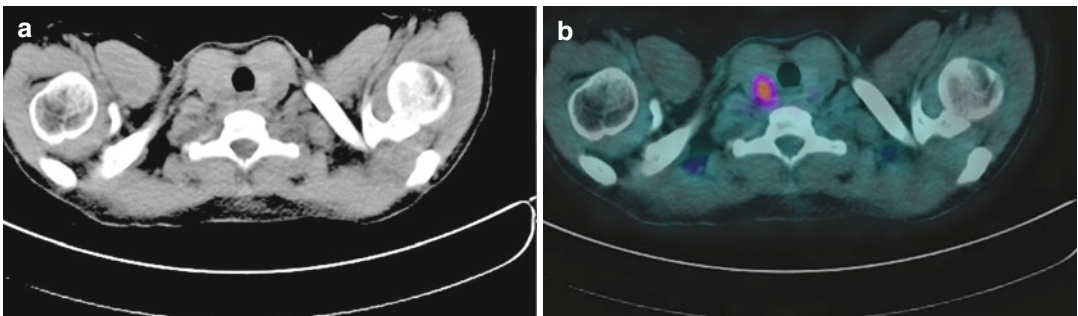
FDG PET-CT scan of a 45-year-old woman with a solitary 10 mm lung nodule in the right upper lobe for further characterisation. Transaxial (a) CT and (b) fused PET-CT images showing moderate focal FDG uptake with a SUV_{max} of 4.3 in the right mid-pole of thyroid. At surgery, a T2N0 22 mm papillary thyroid
